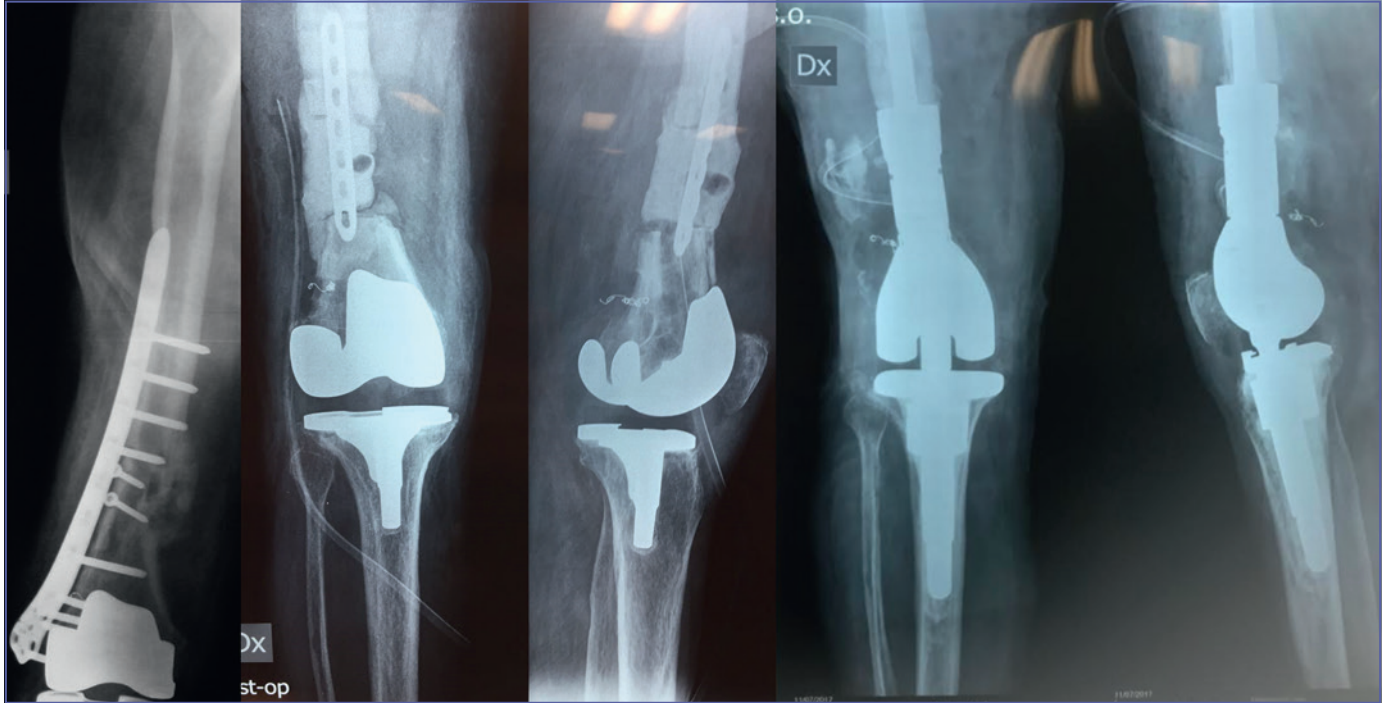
Distal femur infected nonunion treated with a two-stage procedure. A) pre-operative x-rays; B) antibiotic spacer positioning; C) post-operative x-rays.
